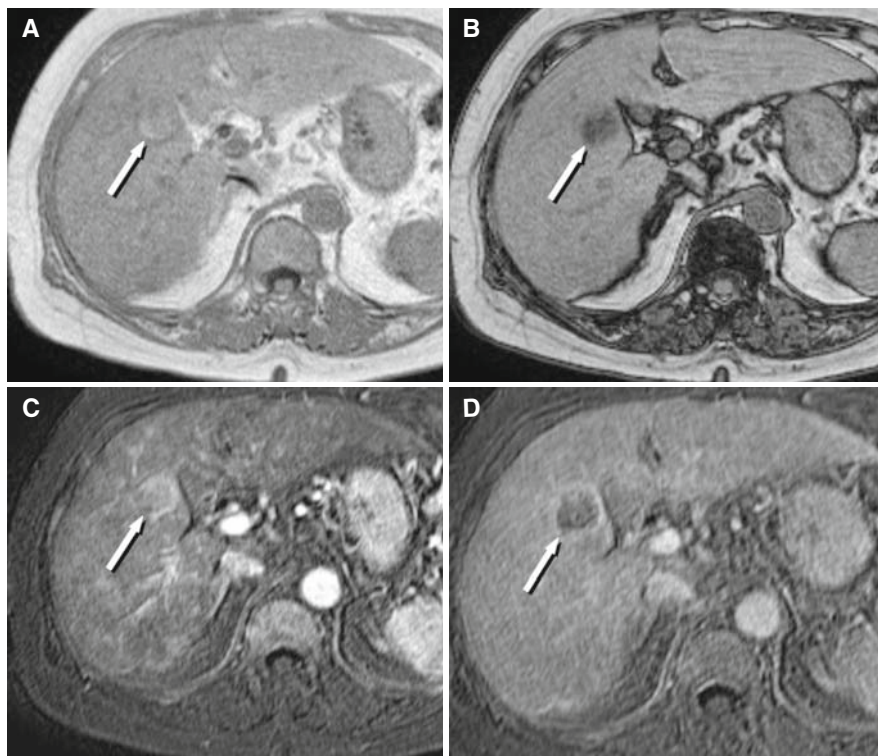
(A) Fat-containing well-differentiated HCC. (B) Out-of-phase T1-weighted image. The mass (*arrow*) shows marked hypointensity indicating signal suppression due to lipid content of the HCC. (C) Gadolinium-enhanced hepatic arterial phase image. The mass is slightly enhanced (*arrow*). (D) Delayed phase image shows the mass as hypointense to liver (*arrow*).
